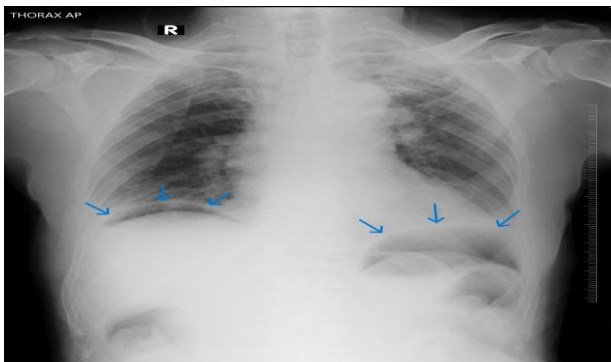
Abdominal X-ray (supine, anteroposterior view) demonstrating radiological findings suggestive of gastrointestinal perforation. Free intraperitoneal air is observed as a radiolucent area beneath the diaphragm (blue arrows), consistent with pneumoperitoneum. Additionally, distended bowel loops are present, indicating paralytic ileus. These findings confirm the diagnosis of gastric perforation, necessitating urgent surgical intervention.
